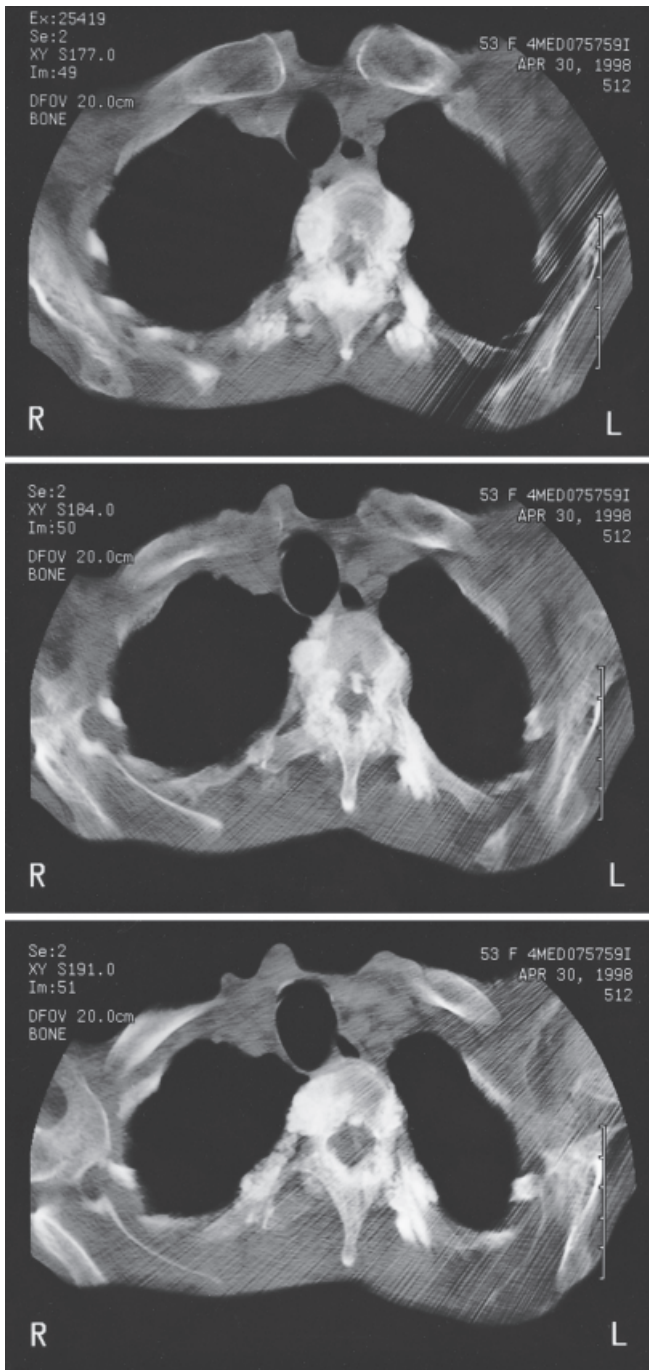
Computed tomography (CT) scan at the Th5–6 level, demonstrating calcific masses around the facet joint, and paraspinal as well as intraspinal calcific masses producing spinal stenosis
